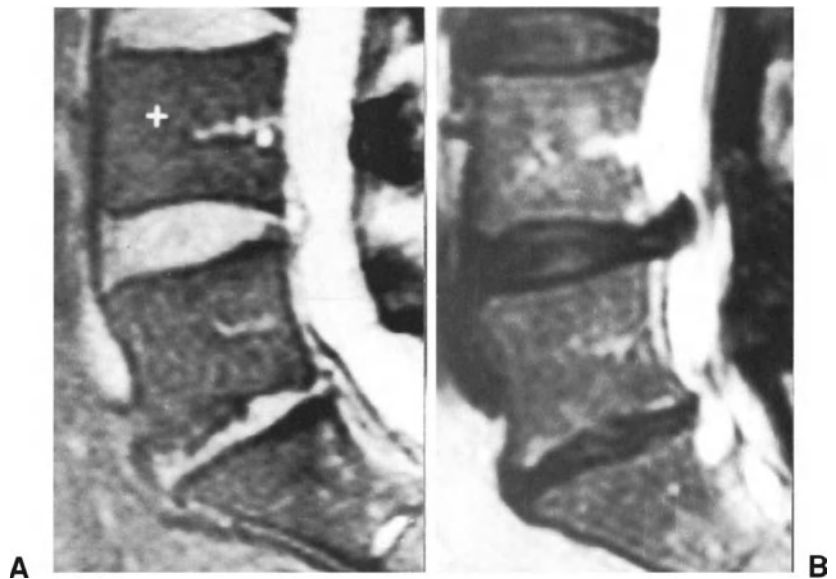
MR images of a patient with recurrent herniation. (A) Preoperative sagittal image revealing a small extruded herniation at L4-L5 level. (B) Sagittal image obtained 15 months after primary discectomy, showing a recurrent herniation which is larger than primary herniation.
